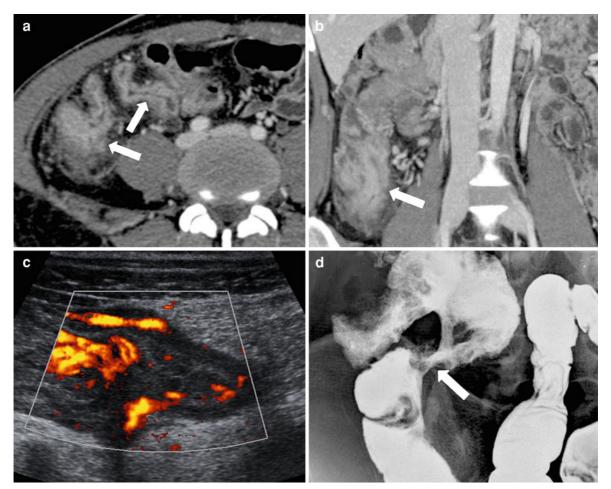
Contrast-enhanced axial (a) and coronal (b) CT image show recurrent Crohn disease with prominent, strongly enhanced mural thickenings and intense surrounding fibrofatty proliferation (*arrows*). Ultrasound (c) demonstrates wall
